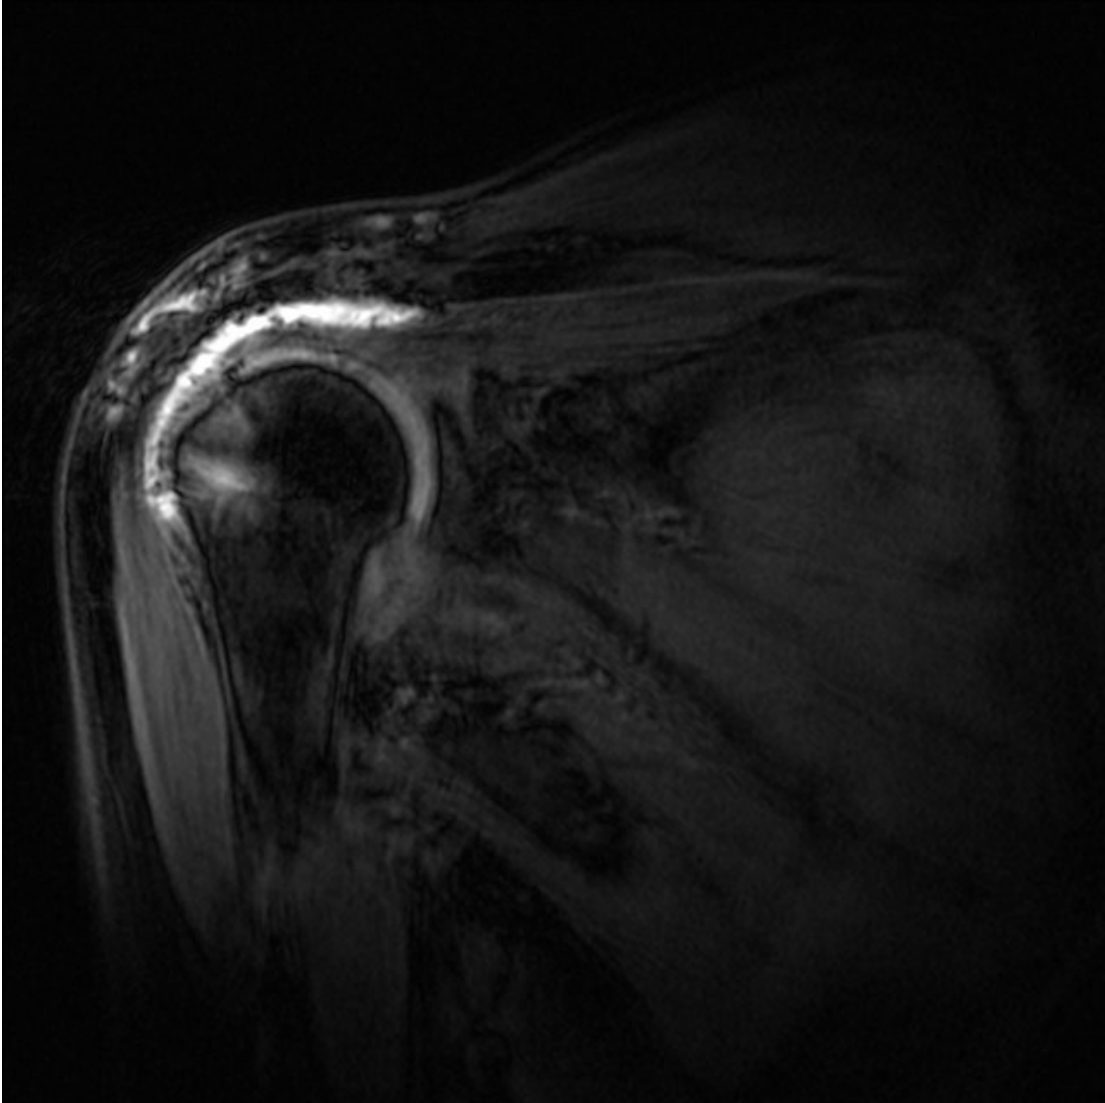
Follow-up MRI picture (11 months postoperative) showing continuity and healing of the cuff tendon to the site of insertion
